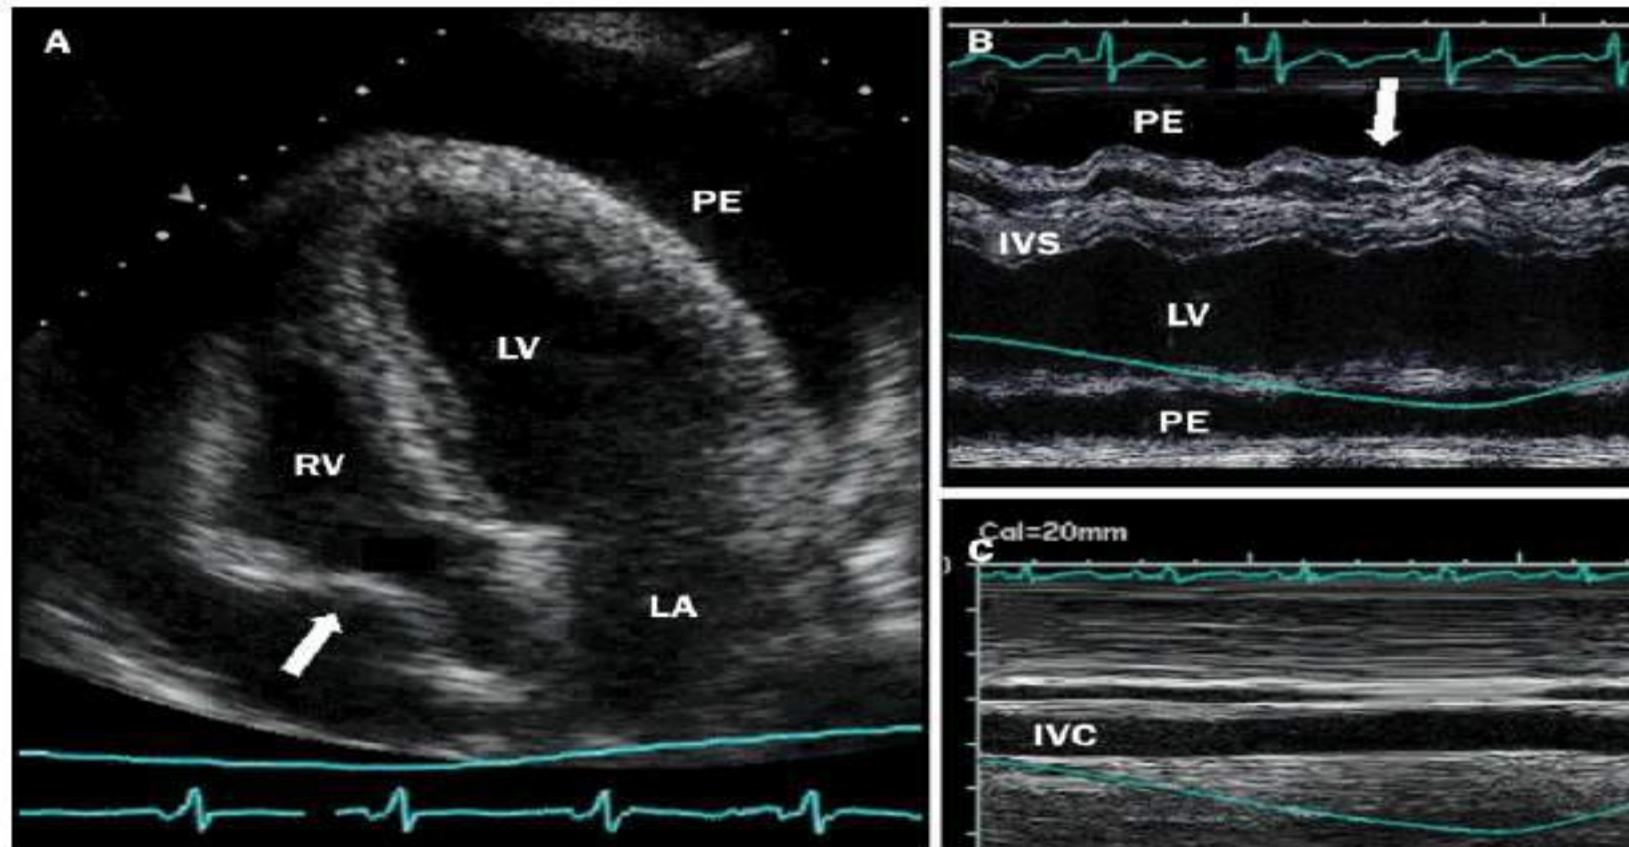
Echocardiographic images of large pericardial effusion with features of tamponade
